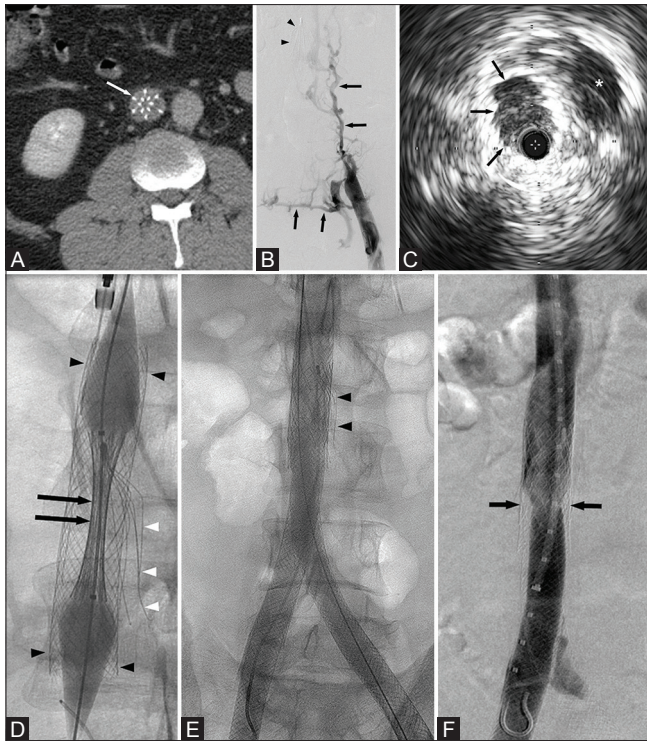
(A-F): (A) Axial contrast-enhanced CT image shows thrombosis of the G2 filter-bearing infrarenal IVC (B) Ascending venogram through left common femoral vein access demonstrates thrombosis of the IVC below the G2 filter (arrowheads) with extensive ascending lumbar and pelvic collaterals (arrows) (C) Intravascular US image reveals narrowing of the IVC with intraluminal thrombosis (arrows) (D) Digital radiograph obtained during deployment of the Palmaz stent (black arrows) at the level of the G2 filter (white arrowheads) to support the previously deployed Wallstents (black arrowheads) (E) Completion venogram shows widely patent IVC and iliac veins. The G2 filter (arrowheads) was displaced laterally. (F) Eighteen month follow-up venogram shows circumferential narrowing of the IVC at the level of the filter (arrows)
